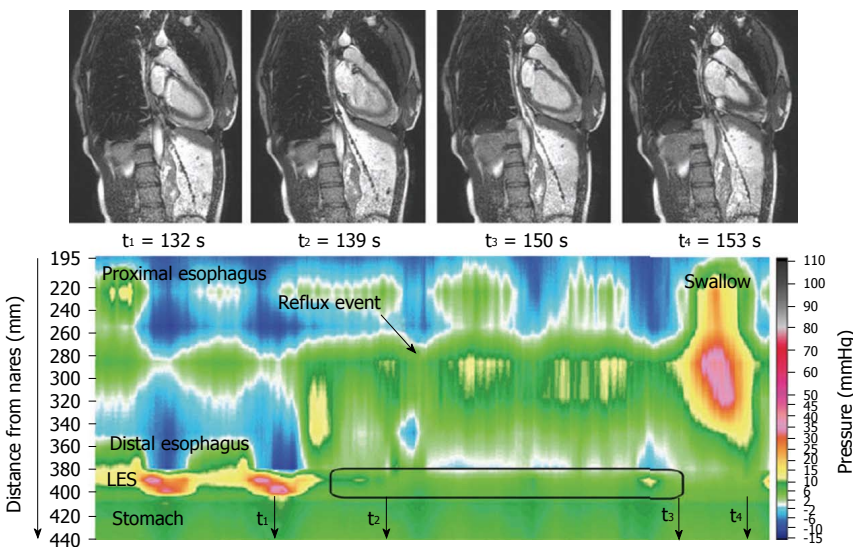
Concurrent high-resolution manometry and magnetic resonance imaging. Representative image demonstrates concurrent high-resolution manometry and magnetic resonance imaging detection of reflux. Note that shortening of the esophagus in the dynamic magnetic resonance images appears to draw the proximal stomach upwards relative to the catheter (above). Reproduced with permission from ref. [11].
